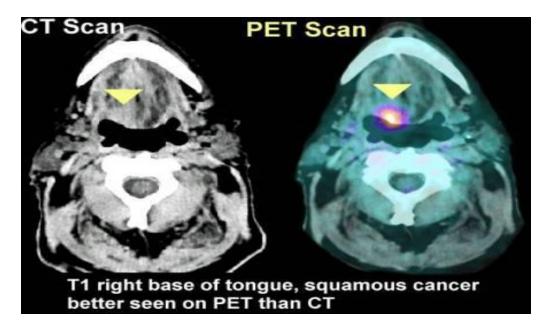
3 Tongue cancer comparative imaging CT Scan versus PER Scan.
